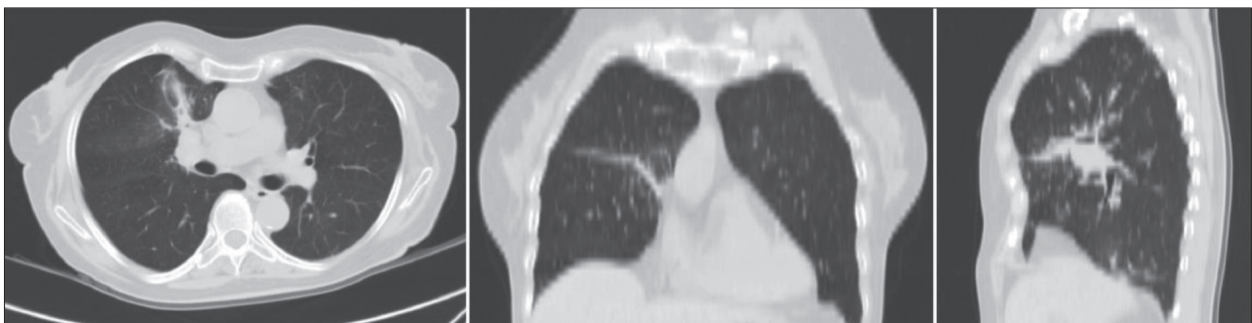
Chest CT after four months of treatment with afatinib
